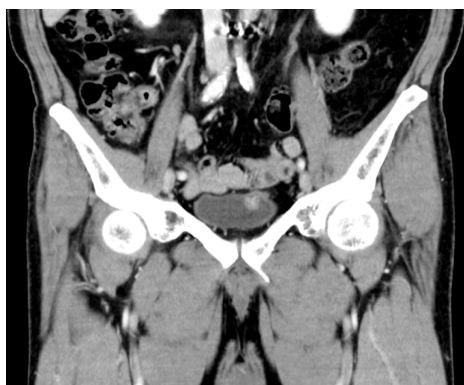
Computed tomography one and a half years after surgery. A tumor lesion about 1 cm in size is seen in the bladder wall.
